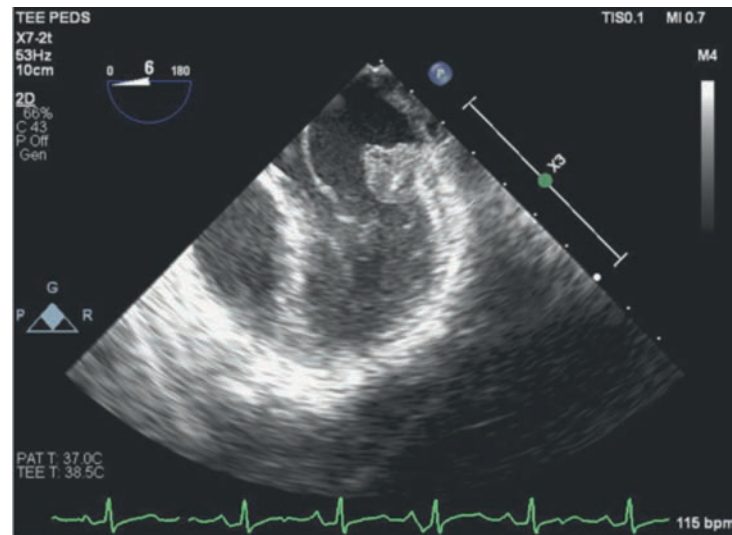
Transesophageal echocardiogram, 4-chamber view. There is a large vegetation seen below the posterior leaflet of the mitral valve.
